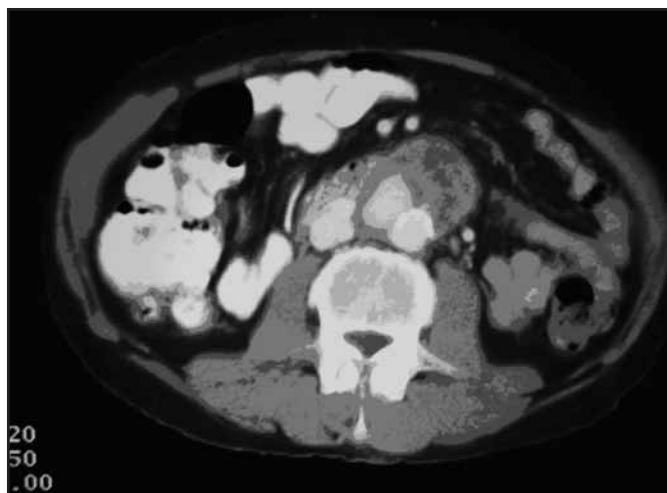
Contrasted CT abdomen showing a pseudoaneurysm in the lower aorta
